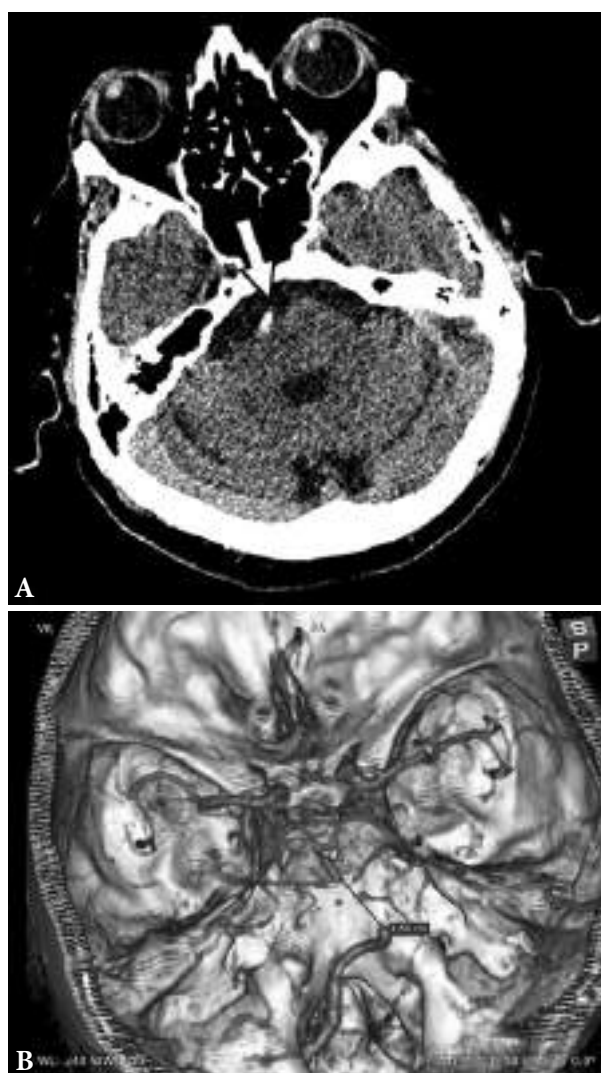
A) Non-contrast CT - hyperdense sign of basilar artery (arrow); B) CTA 3D reconstruction showing the basilar artery occlusion of 1.6 cm in length
